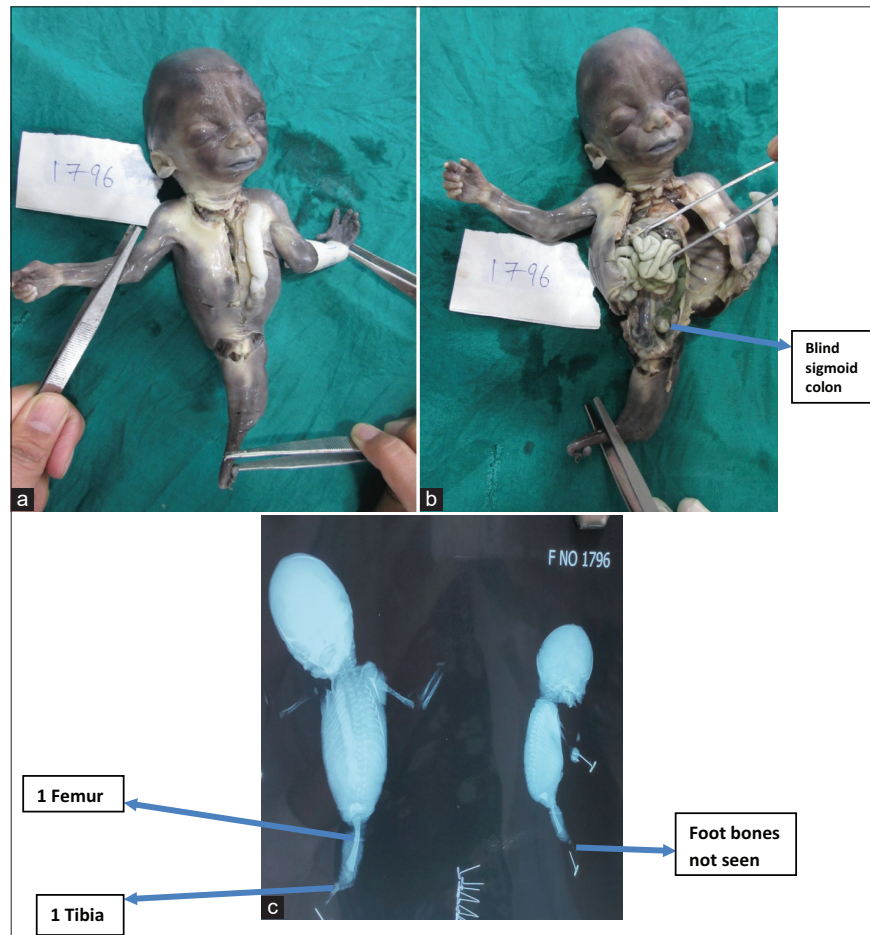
Case III - (a and b) Anterior aspect and internal features of fused lower limb, respectively. (c) Radiographic examination
